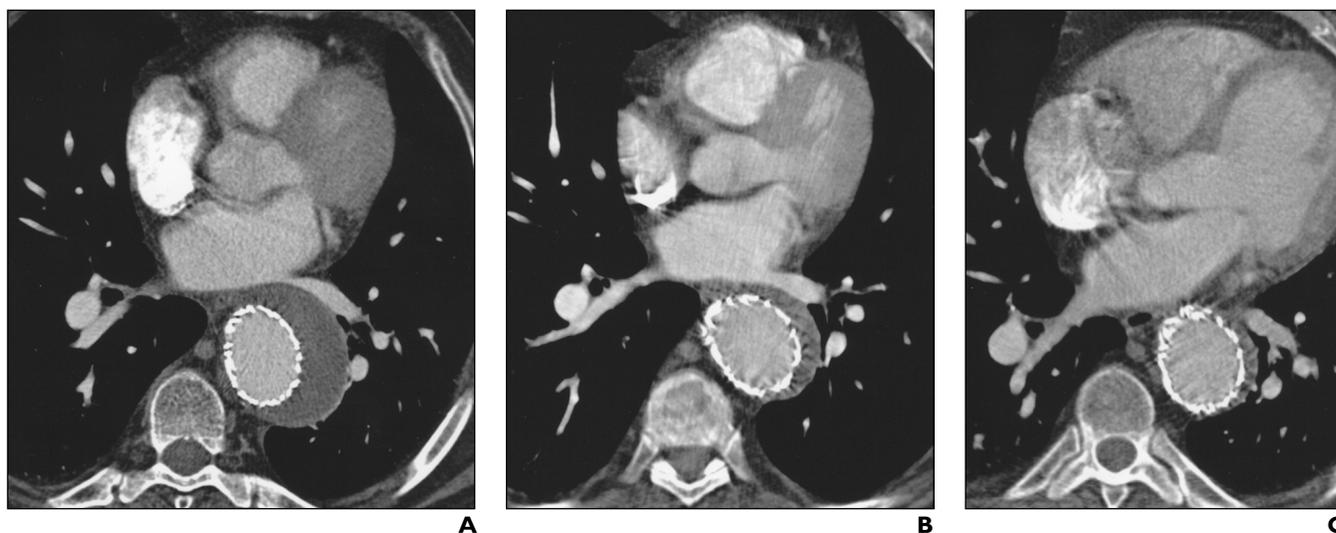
66-year-old man who presented with descending thoracic aortic aneurysm of 6.1 cm at maximal diameter. A, Contrast-enhanced axial CT scan obtained after stent-graft repair shows initial thrombus volume before hospital discharge to be 164 mL. B and C, Contrast-enhanced axial CT scans obtained at 1-year (B) and 2-year (C) follow-ups show thrombus volume to have decreased to 39 and 31 mL, respectively.
